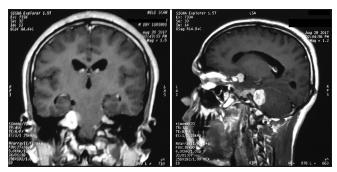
Coronal and sagittal magnetic resonance imaging of the brain showing multiple meningiomas and bilateral acoustic schwannomas
